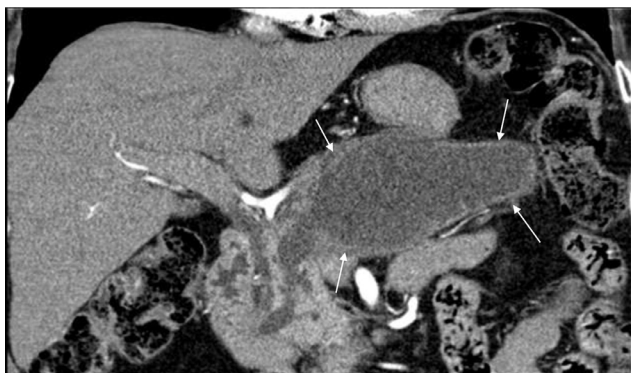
Coronal reconstructed contrast enhanced CT of the abdomen in June 2017 shows further enlargement of the cystic pancreatic mass occupying the majority of the pancreatic body and tail (arrows).
